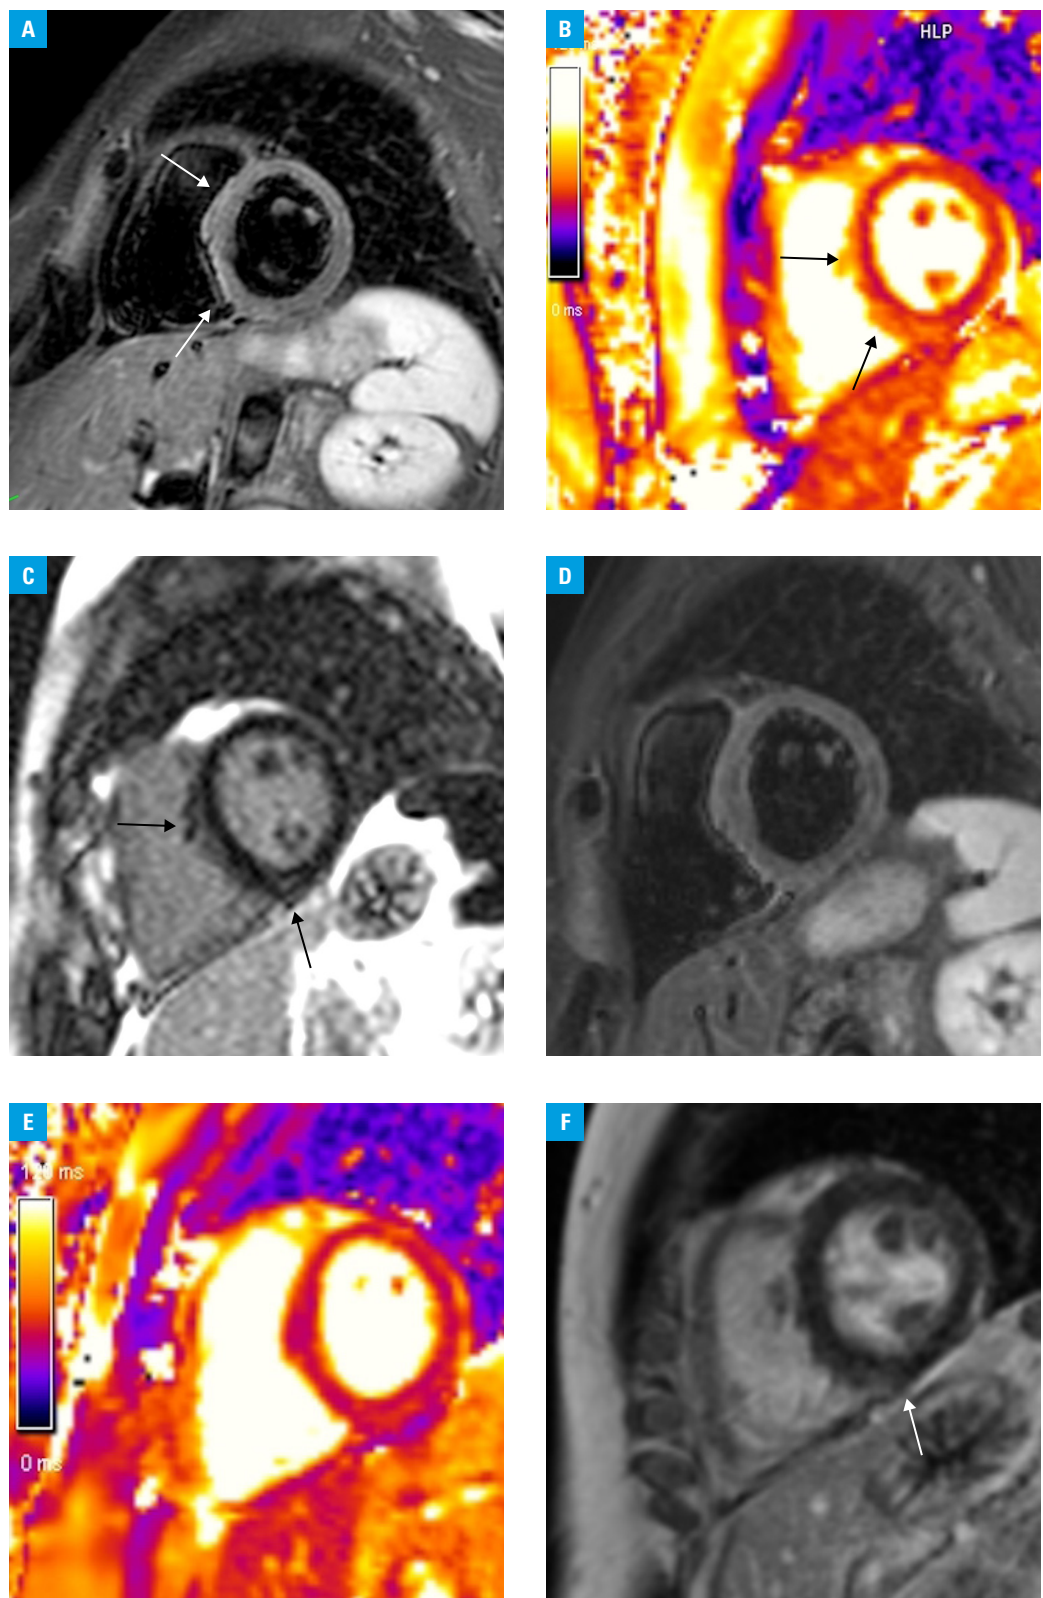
A–C – baseline (2016) and early follow-up (2018) cardiac magnetic resonance imaging; A – T2-weighted short-tau inversion recovery (T2STIR) sequence showing increased signal of the myocardium (arrows) consistent with myocardial edema (baseline, 2016); B – elevated global T2 relaxation time (54 ms; institutional reference range, 39–49 ms) with local (arrows) increase of the T2 relaxation time (segmental region of interest average T2, 59 ms) in the basal inferoseptal segment consistent with acute injury/ongoing inflammation (early follow-up, 2018), paralleled by subtle intramyocardial areas of irreversible damage (inflammatory necrosis/fibrosis) as shown by late gadolinium enhancement (C, arrows); D–F – follow-up cardiac magnetic resonance imaging (2020); D – T2STIR sequence showing normalized signal of the myocardium with no features of myocardial edema; E – normalized T2 relaxation time—no unequivocal features of acute injury/ongoing inflammation (global T2 relaxation time, 49 ms); F – subtle intramyocardial areas of irreversible damage (inflammatory necrosis/fibrosis) can still be noticed on late gadolinium enhancement imaging (arrow).
